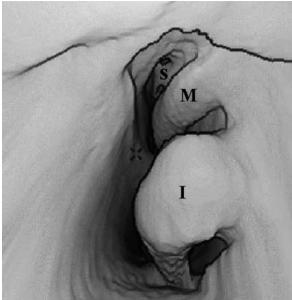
CT virtual endoscopy of the nasal cavity created with a perspective positioned in the rynopharynx (a). The arrow indicates the orientation of the virtual endoscope. The right superior (s), middle (M) and inferior (I) turbinates are shown (b)
